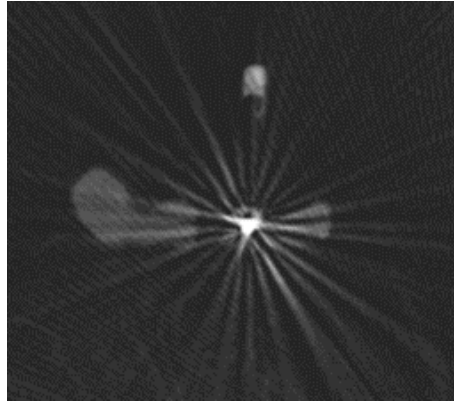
Streak artifacts in the CBCT scan due to the metal screw in the pubic bone of the sawbone model.
